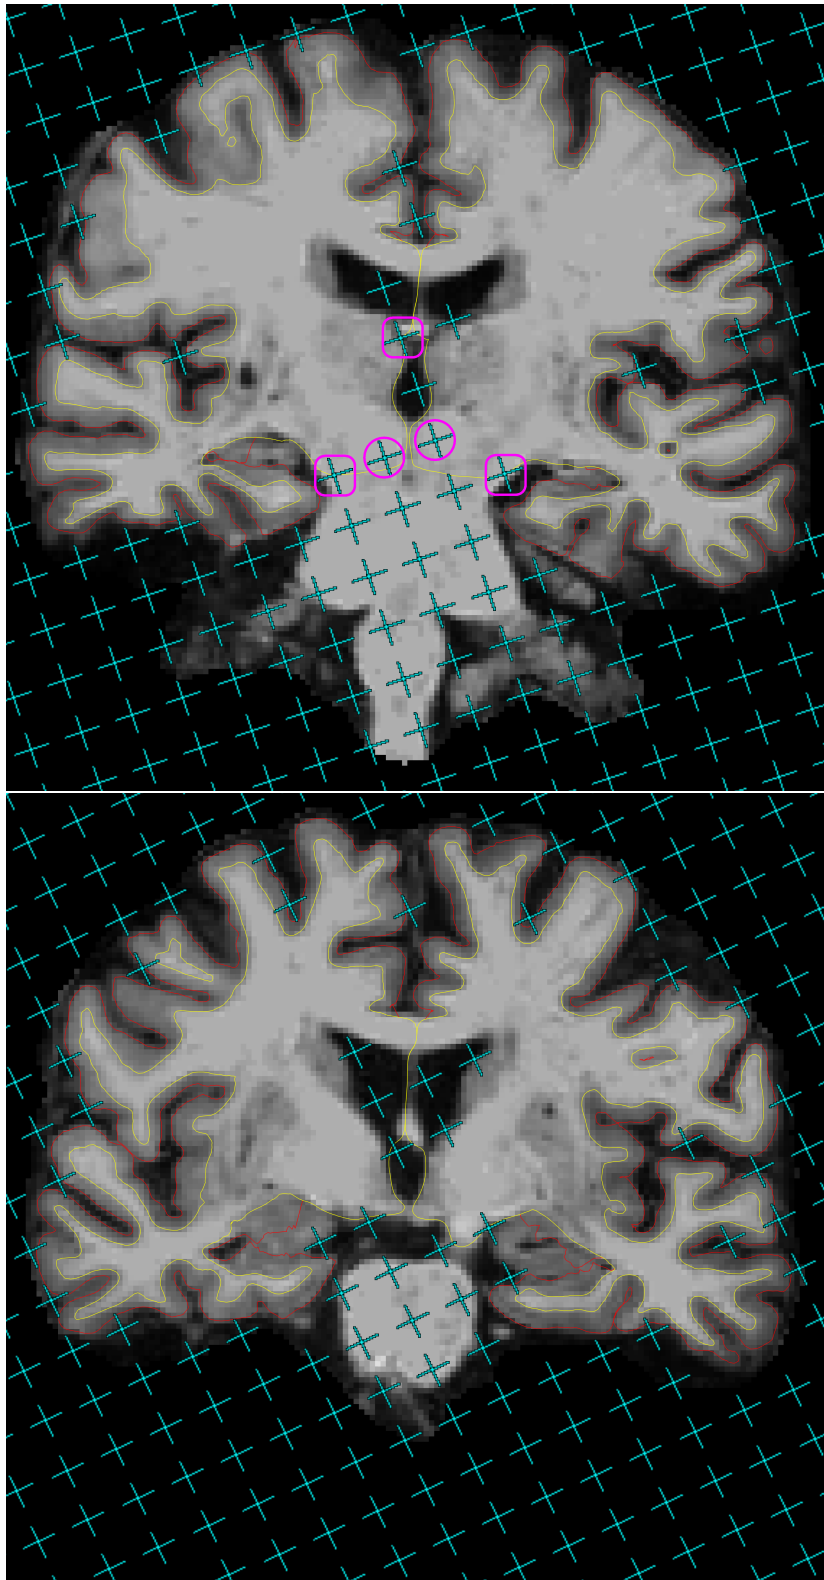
On the 9th and 10th slices of one brain MR image in the coronal view, uncounted test points (cyan) which miss the cerebral parenchyma or hit the ventricles are overlaid onto pial profiles (red lines) segmented by FREESURFER. Circles (pink) mark the uncounted test points which fall inside the grey matter boundaries (red lines) and rounded rectangles (pink, racetrack-like) mark the test points hitting exactly on the grey matter boundaries.
